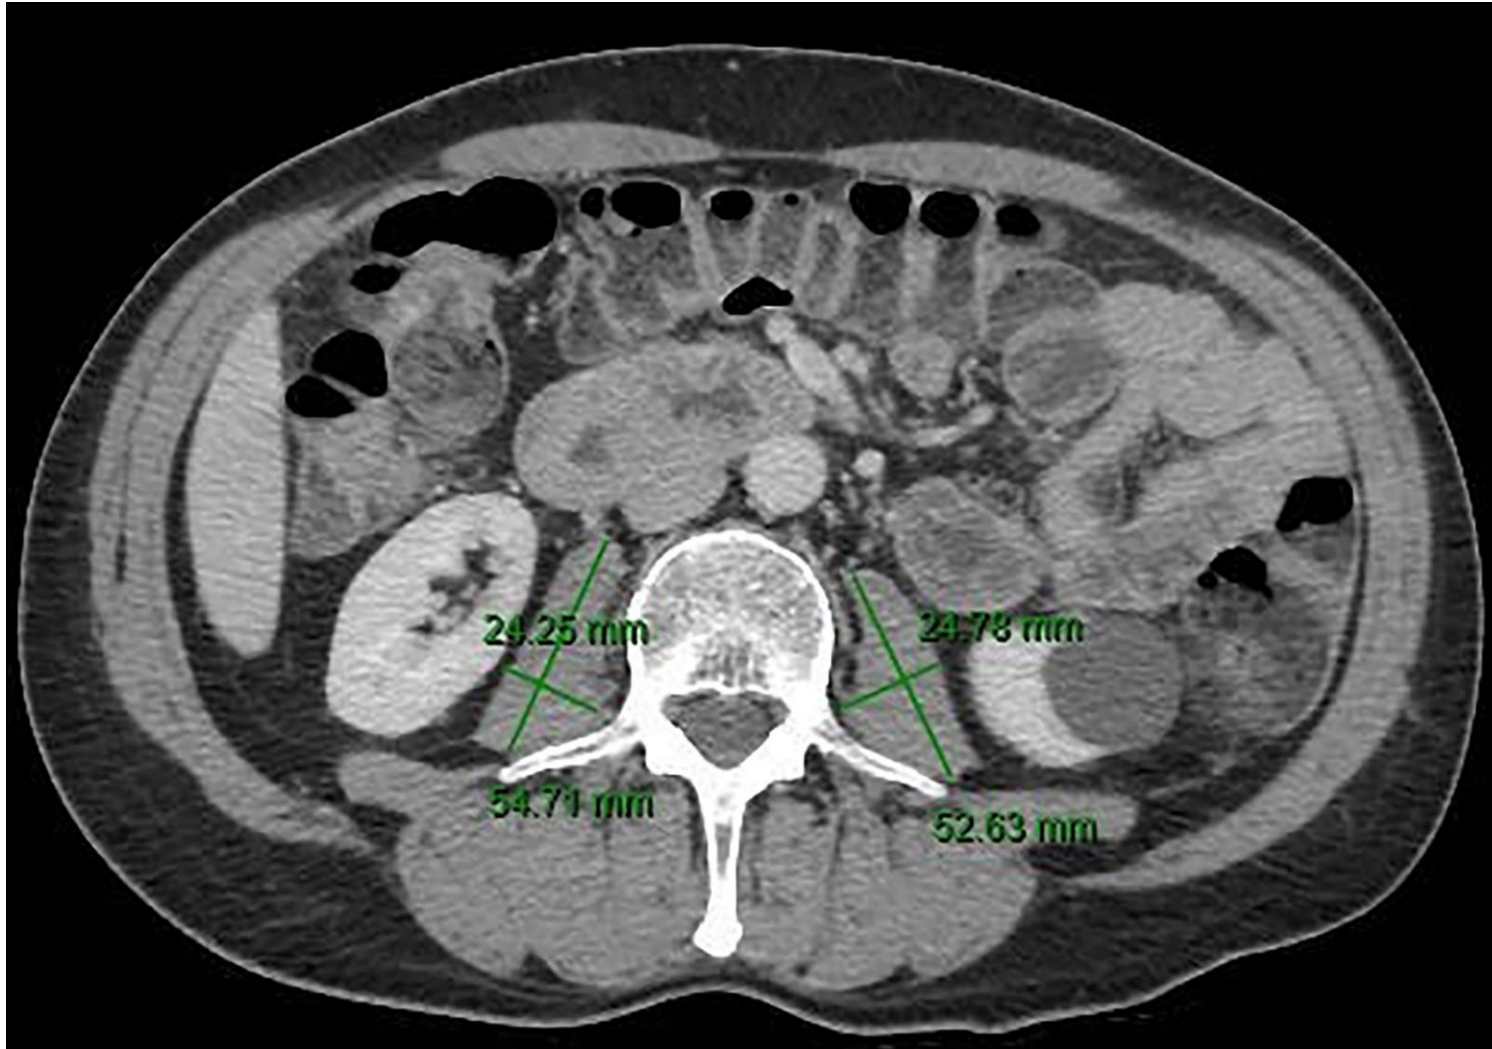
Assessment of total psoas area index (TPAI). TPAI was assessed by measuring the longest anterior to posterior and transverse diameter (green lines) of the right and left psoas muscle on an axial computed tomography (CT) slice at the level of the 3rd lumbar vertebrae and normalized for the patients' height squared.
